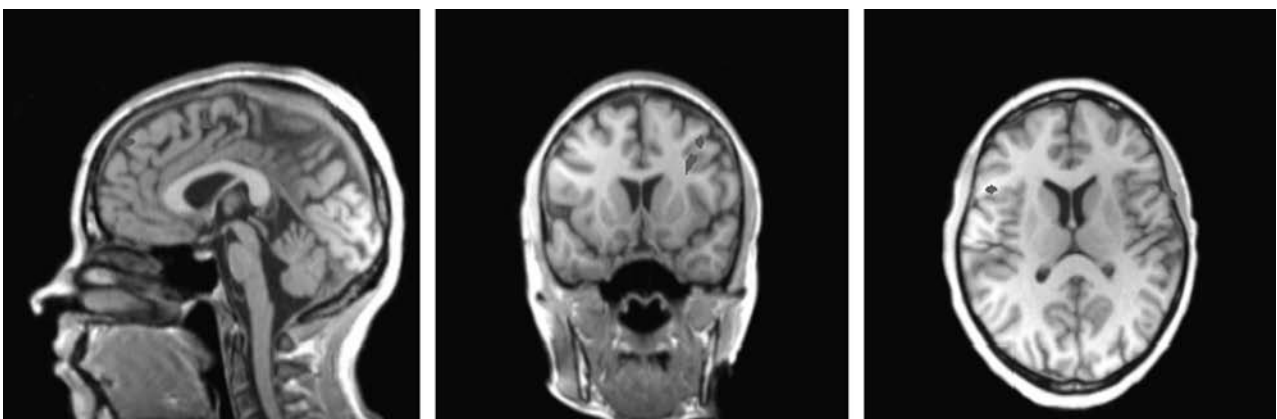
Functional MRI activation during the presentation of the OCD-related pictures in the healthy control subject (first session, OCD-related pictures minus neutral pictures; $x = -2$, $y = 10$, $z = 13$; $P(\text{uncor}) < 0.001$).
